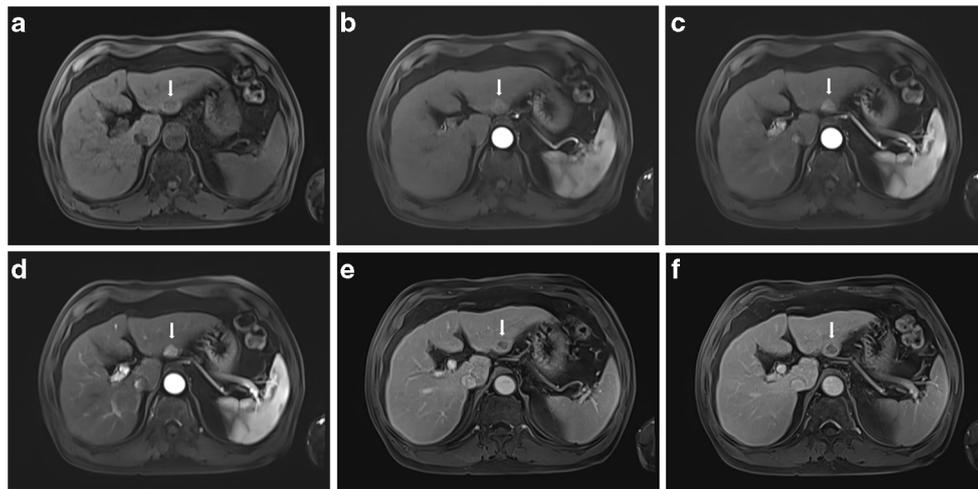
Sixty-nine-year-old man with liver cirrhosis on gadoxetic acid-enhanced liver MR examination using mC-VIBE sequence without view-sharing. MR images in (a) pre-contrast, (b) first arterial, (c) second arterial, and (d) third arterial phases, (e) portal venous phase, and (f) transitional phase. Note no motion artifact for all arterial phases. MR images
